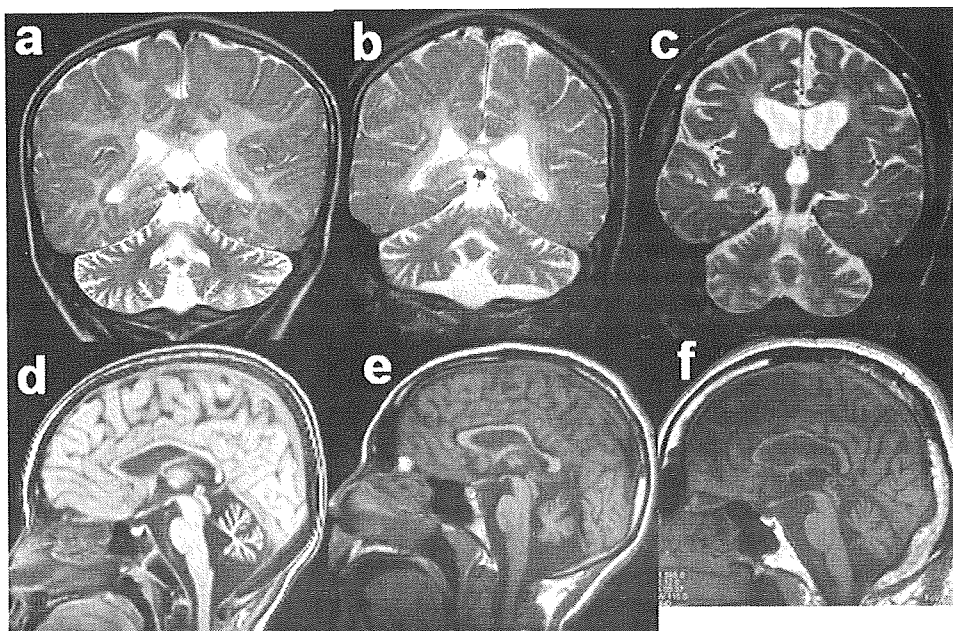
T2-weighted coronal MRI (a, b, c) revealing high-intensity areas in the cerebral white matter and diffuse cerebellar cortical atrophy. Cerebral atrophy can be observed only in patient 3. T1-weighted sagittal MRI (d, e, f) reveals atrophy of the cerebellar vermis and hypoplasia of the myelinated corpus callosum in all cases (a, d: patient 1; b, e: patient 2; c, d: patient 3).
